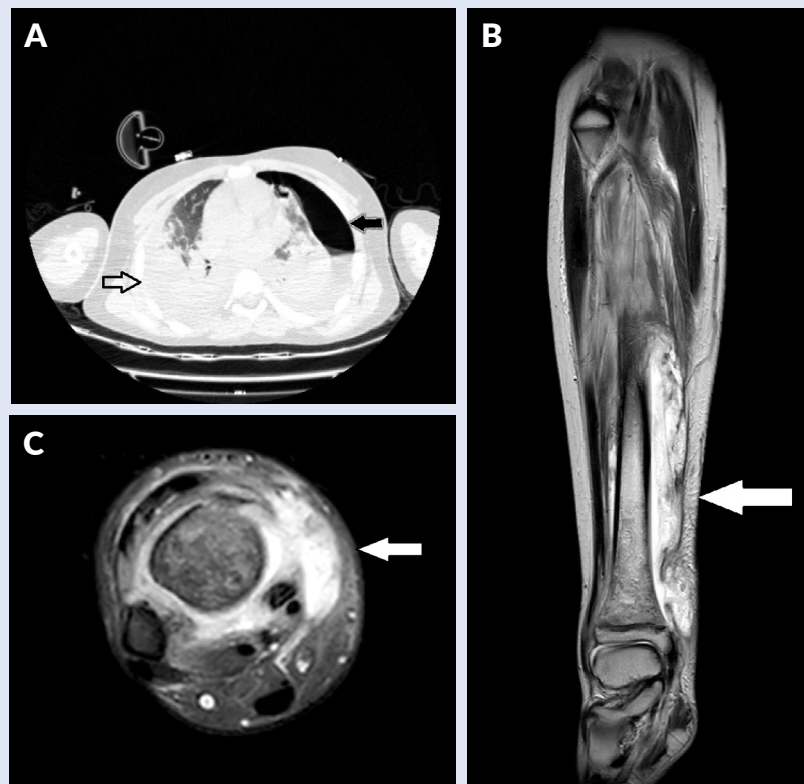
Panel A: Axial HRCT chest shows diffuse bilateral consolidations along with left hydropneumothorax (black arrow) and right hydrothorax (white arrow). Panel B and C: Coronal T2 (B) and axial STIR (C) MR images of right leg show diffuse marrow edema along the entire length of tibia predominantly affecting the distal meta-diaphysis with adjacent subperiosteal collection along with diffuse soft tissue edema predominantly on medial aspect (indicated by arrow).
